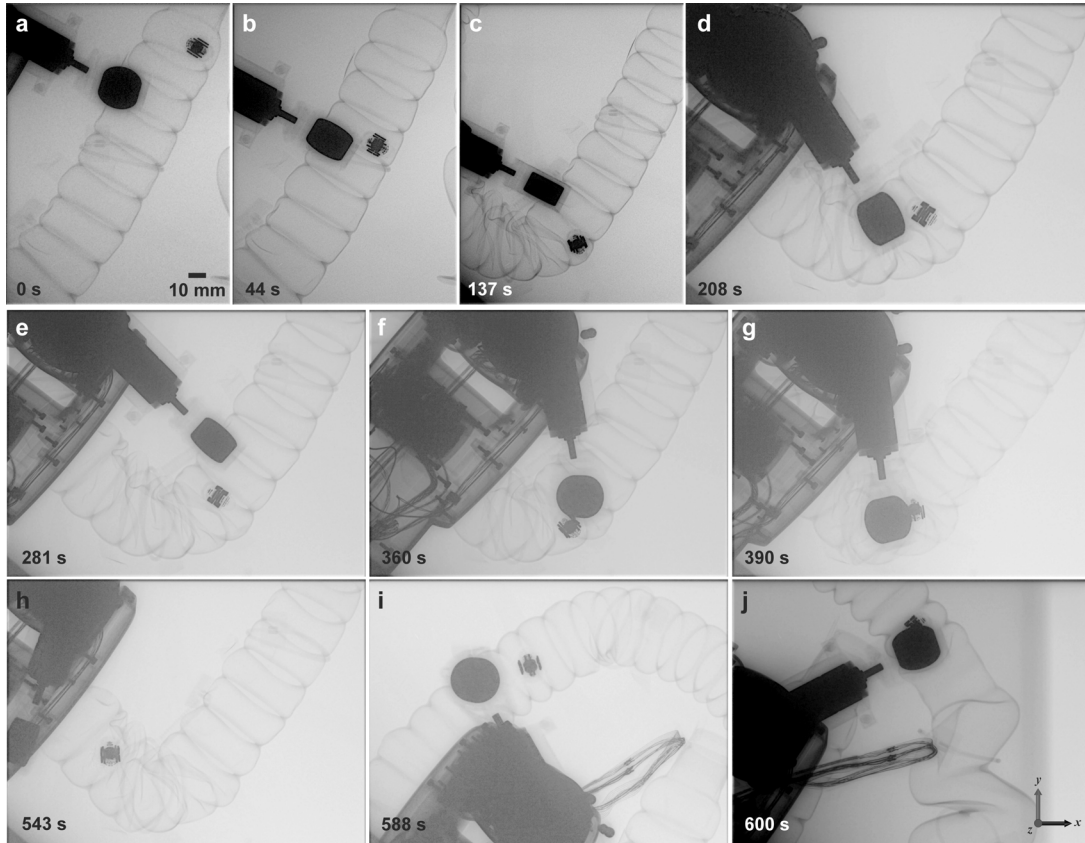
This figure is obtained from the manual control experiments with the C-arm in session 2. It was done by splicing together specific times from the x-ray fluoroscopy videos.
